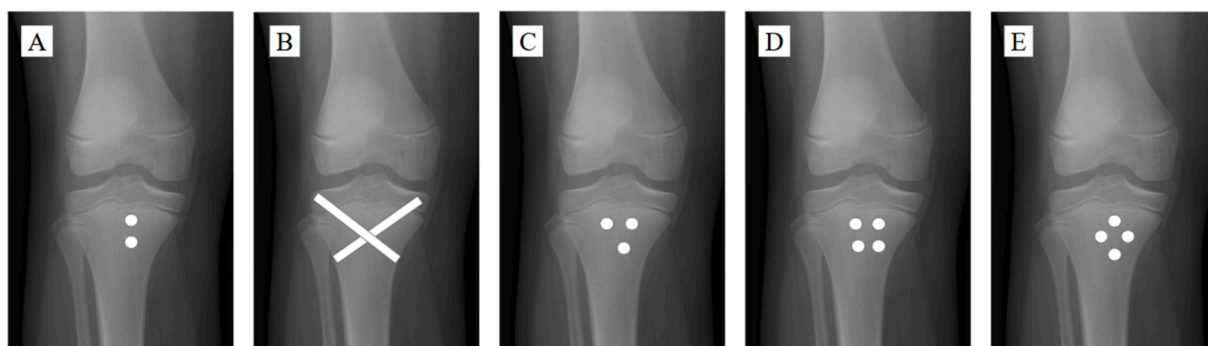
Anterior/Posterior radiographs depicting common methods for screw fixation of type IV tibial tubercle avulsion fractures. (A) Vertical, (B) X, (C) Inverted triangle, (D) Box, (E) Diamond.
